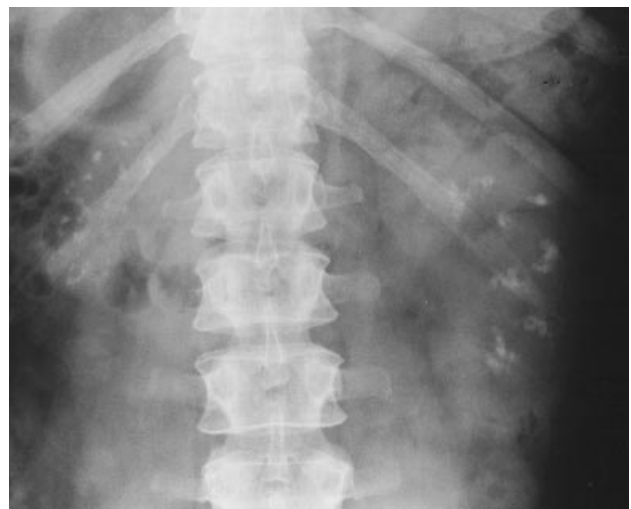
Plain abdominal radiograph showing extensive nephrocalcinosis in a medullary distribution, with a small right kidney in the brother.
